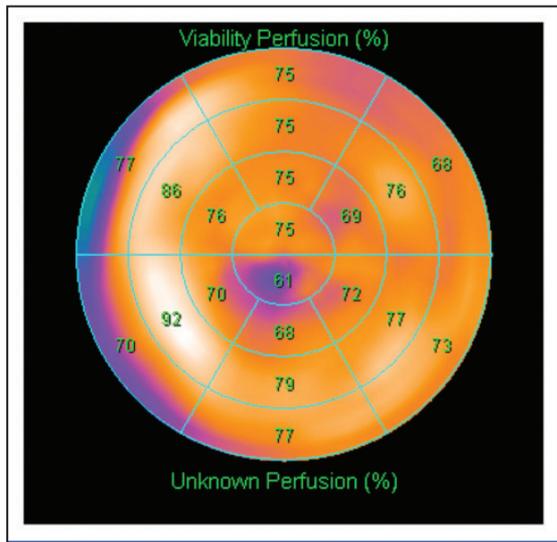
An example of polar map demonstrating the percentage of FDG distribution in each segment.
